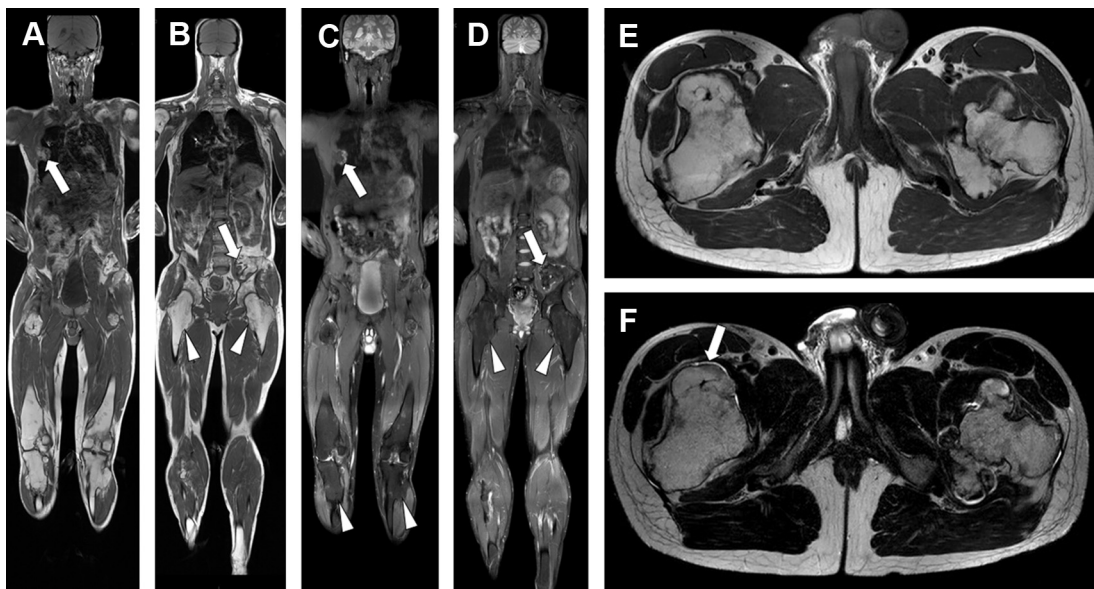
WB MR imaging from a 22-year-old male patient with hereditary multiple exostoses. Coronal T1 (A, B) and STIR (C, D) MR imaging of the WB shows severe deformities predominantly at the level of the hip and knee joints (arrowheads in B and D) and involving the ribs (arrows in A and C) and the left iliac bone (arrows in B and D). Dedicated transverse T1-weighted (E) and T2-weighted (F) MR imaging shows lesions of the proximal femurs and allows delineation and measurement of the cartilage caps of the exostoses (arrow in F); these caps remain very thin, ruling out malignant degeneration.
